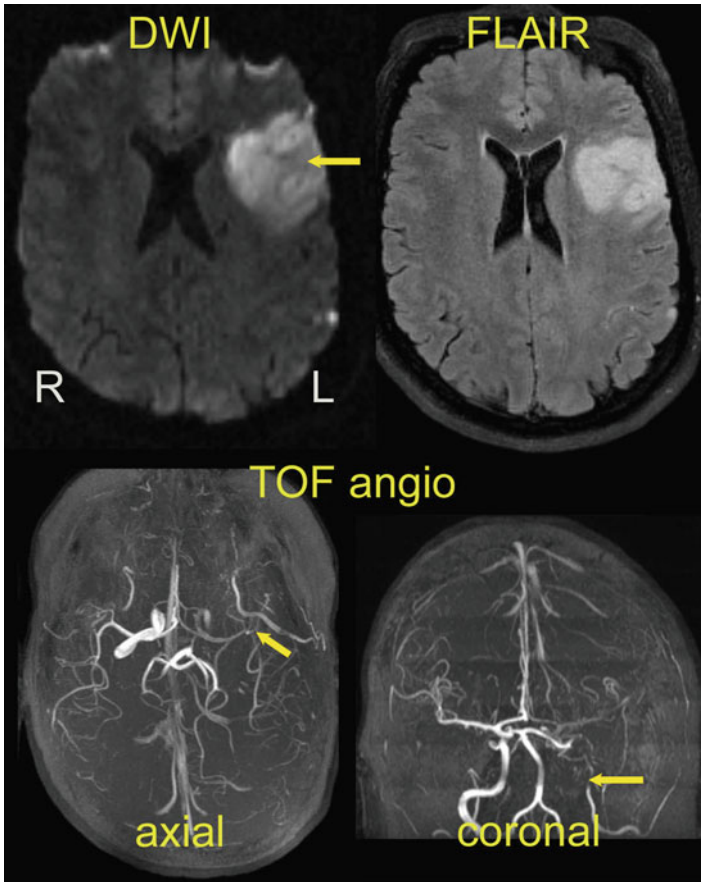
MR images from a 48-year-old woman with a near occlusion in the left internal carotid artery and an acute stroke. *Top left:* Diffusion-weighted image (DWI) shows an area of restricted diffusion and consequent hyperintensity in the left frontal lobe. *Top right:* The fluid-attenuated inversion recovery (FLAIR) image shows hyperintensity in the corresponding location when compared to the DWI scan. *Bottom:* Time of flight angiography (TOF angio) images in the axial and coronal plane show reduced flow through the arteries in the left hemisphere. *Arrows* indicate location of near occlusion
